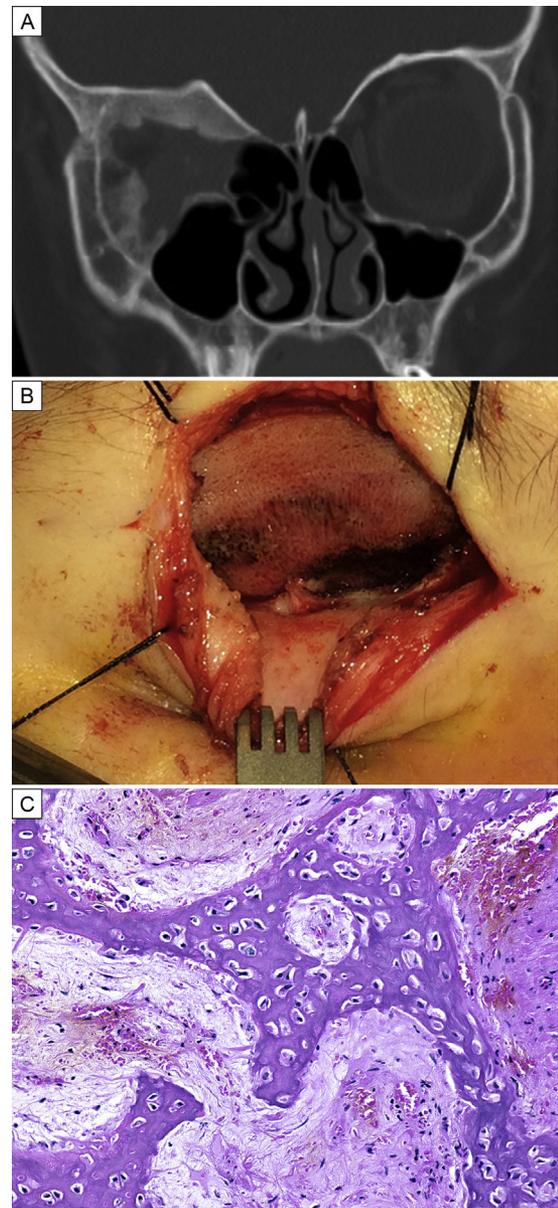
A, Four months after orbital exenteration, computed tomography revealed progressive expansion of the right orbital roof. B, Surgical photograph of the abnormal superior orbital bone in the previously exenterated right orbit. C, Pathology of superior orbital bone revealed mild pleomorphism and atypia, osteocyte crowding, and a lack of osteoblast rimming, which raised concern for a low-grade osteosarcoma or an atypical reactive condition.
